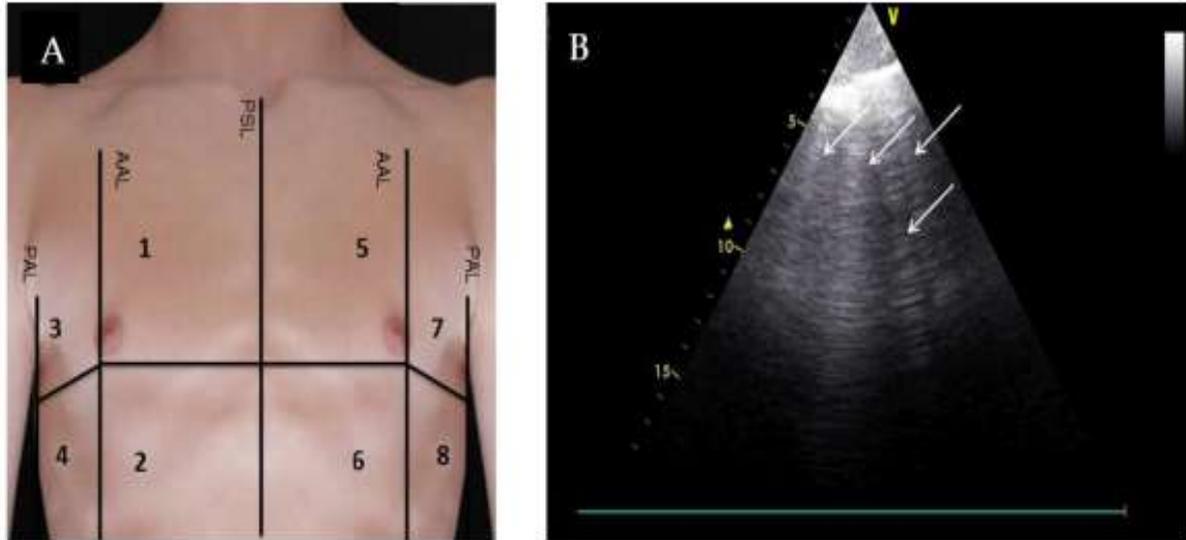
[A] Division of the thorax in eight lung zones. PSL: parasternal line; AAL: anterior axillary line; PAL: posterior axillary line; [B] Example of a lung ultrasound loop of quadrant 1 at admission assessed as a positive region due to the appearance of ≥ 3 B-lines.
